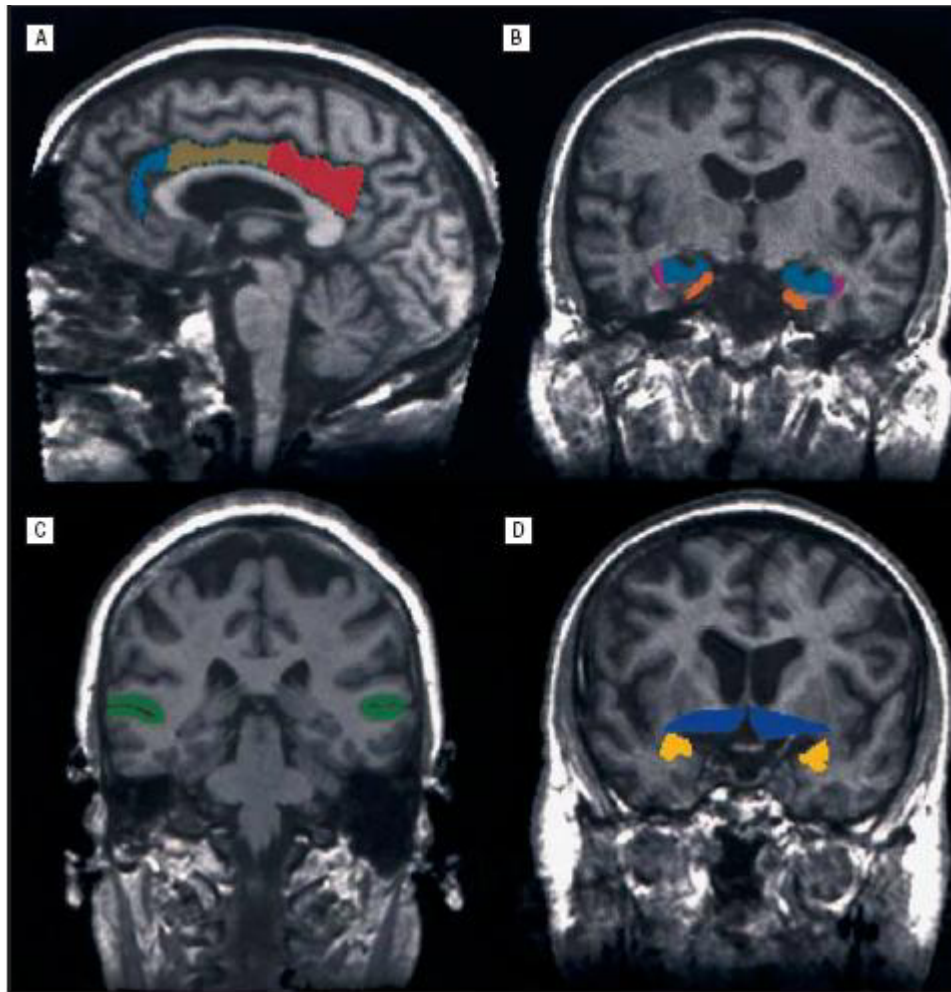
The locations of the 9 volumes of interest used for the magnetic resonance imaging and magnetic resonance imaging-guided single-photon emission computed tomography data: rostral anterior cingulate (blue), caudal anterior cingulate (green), and posterior cingulate (red) (A); temporal horn (purple), hippocampus (blue), entorhinal cortex (orange) (B); basal forebrain (blue) and amygdala (yellow) (C); and the banks of the superior temporal sulcus (green) (D).
